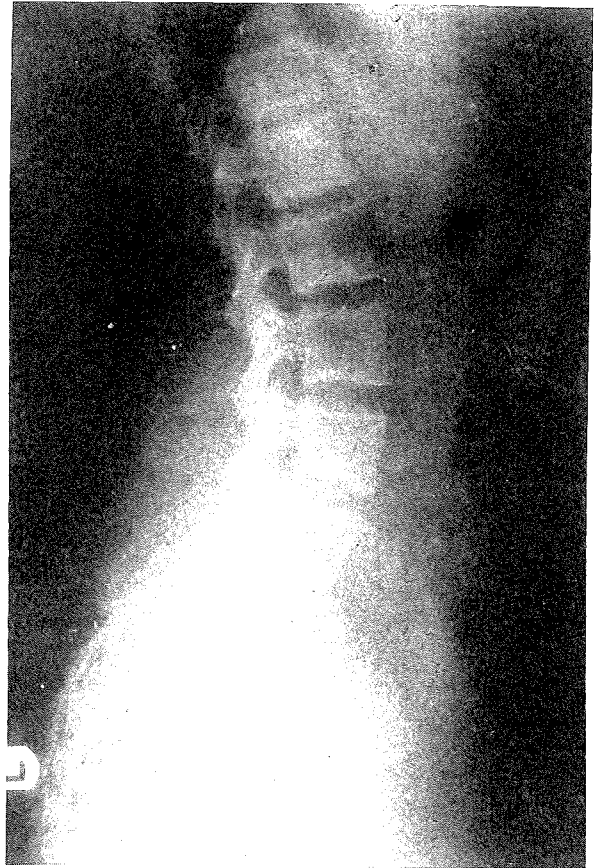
Lateral x-ray abdomen - shows the Copper T device outside the uterus but within the pelvis.
